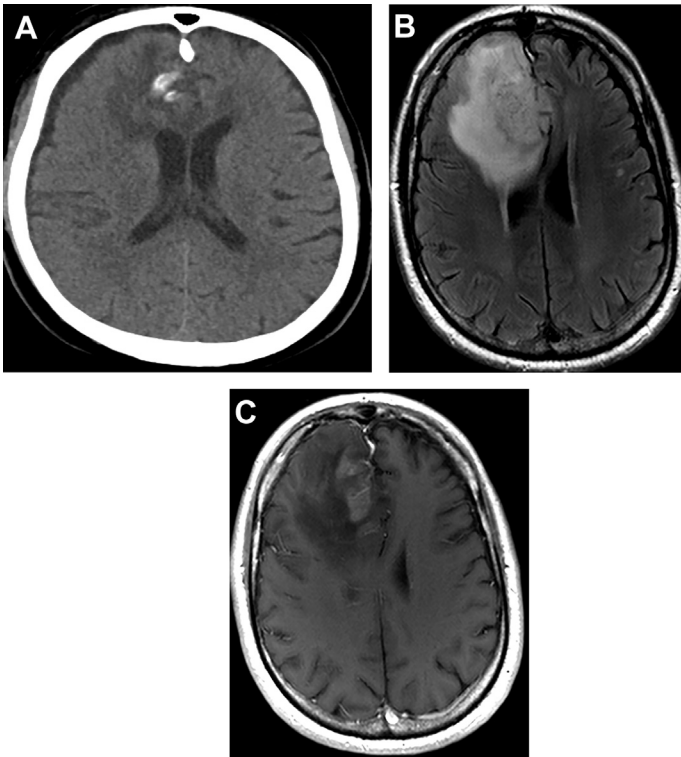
Codeleted oligodendroglioma. A 39-year-old man with right frontal lobe oligodendroglioma, *IDH*-mutant, and 1p/19q codeleted, showing characteristic imaging features. Axial CT image (A) shows the right frontal lobe calcified mass with mild mass effect on the ventricular system. Axial FLAIR image (B) shows a hyperintense infiltrative mass in the right frontal lobe, which shows mild fluffy enhancement on its medial side on postcontrast T1 weighted images (C).
